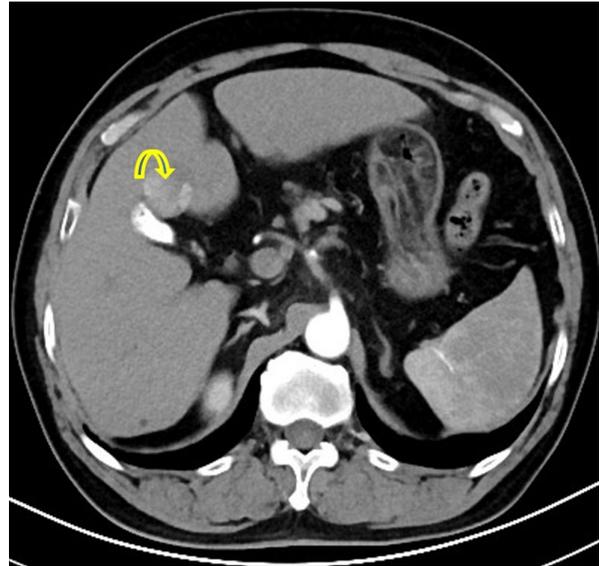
The multiphase computed tomography of hepatitis B positive 49-years-old man. The arrow indicates 1.7 cm enhancement during the arterial phase in the seventh segment of the liver.
